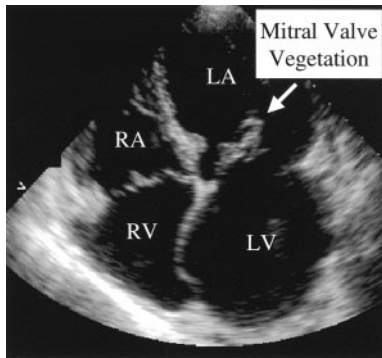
Mitral valve vegetation shown by echocardiogram. The vegetation is the mass seen in the dark space between the left atrium (LA) and left ventricle (LV). RA indicates right atrium; RV, right ventricle.
